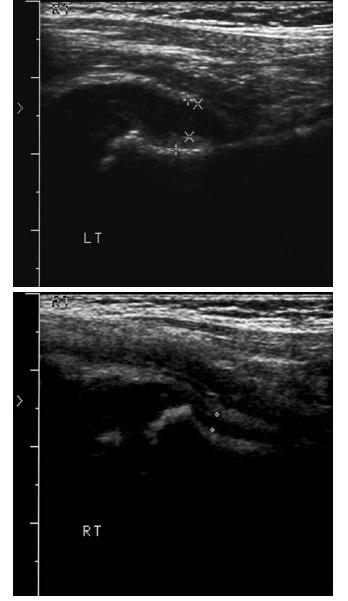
Sagittal sonograms of the left and right hip.
